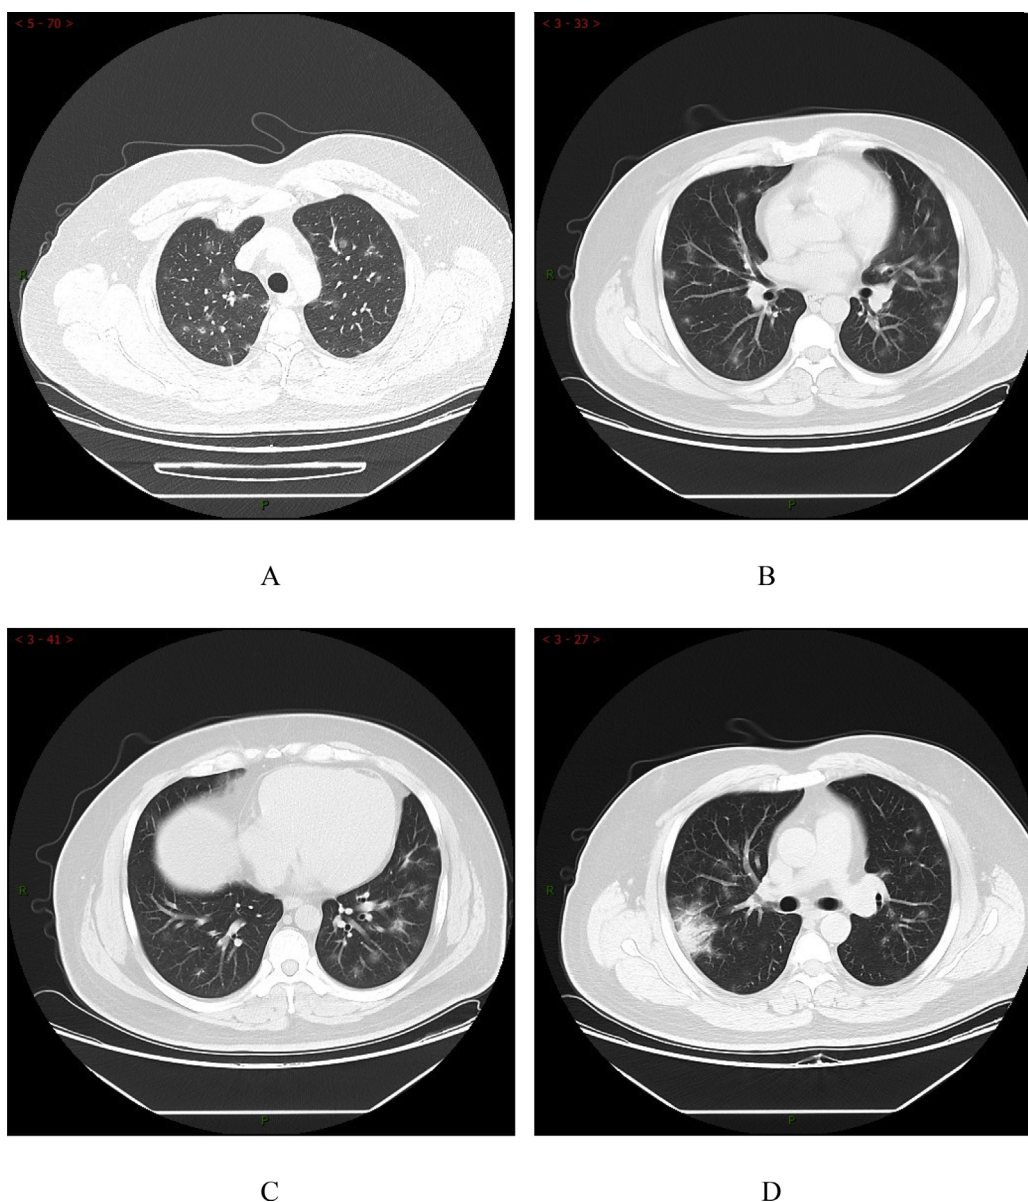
Chest CT on January 9th, 2020. A-C, Images showed multiple ground-glass opacities at bilateral lungs; D, consolidation lesions could be seen in the posterior segment of the right upper lobe.
